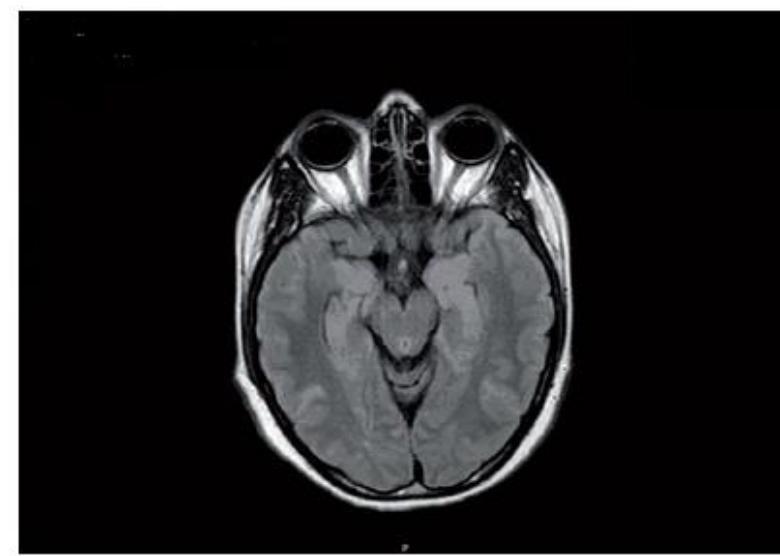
Encephalic MRI: It highlights the disappearance of all lesions.
